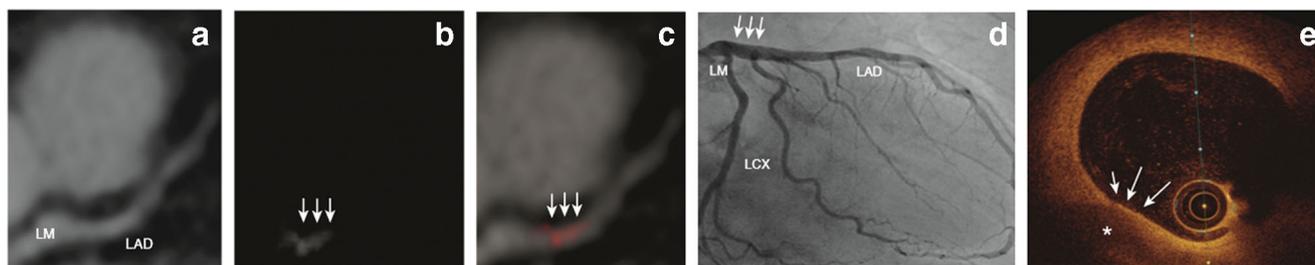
Detection of vulnerable plaque using gadofosveset enhanced cardiac magnetic resonance imaging (CMR). a CMR angiography of left main (LM) and left anterior descending artery (LAD). b Gadofosveset enhancement in LM (white arrows). c Fused image of CMR and vessel wall image. d X-ray coronary angiography showing
